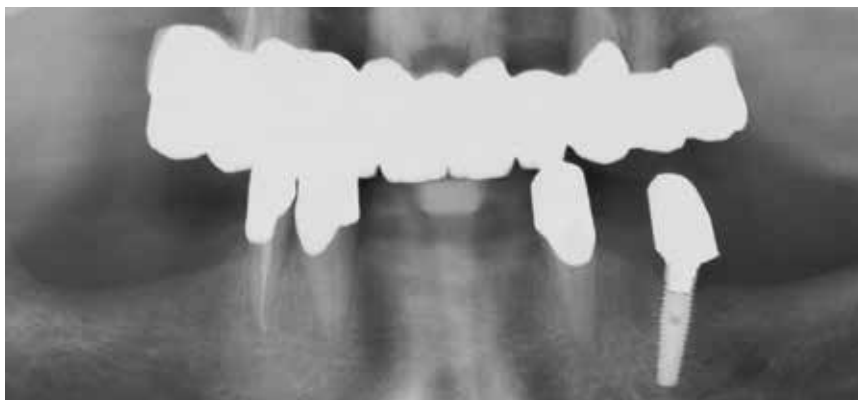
X-ray image after end of treatment.
